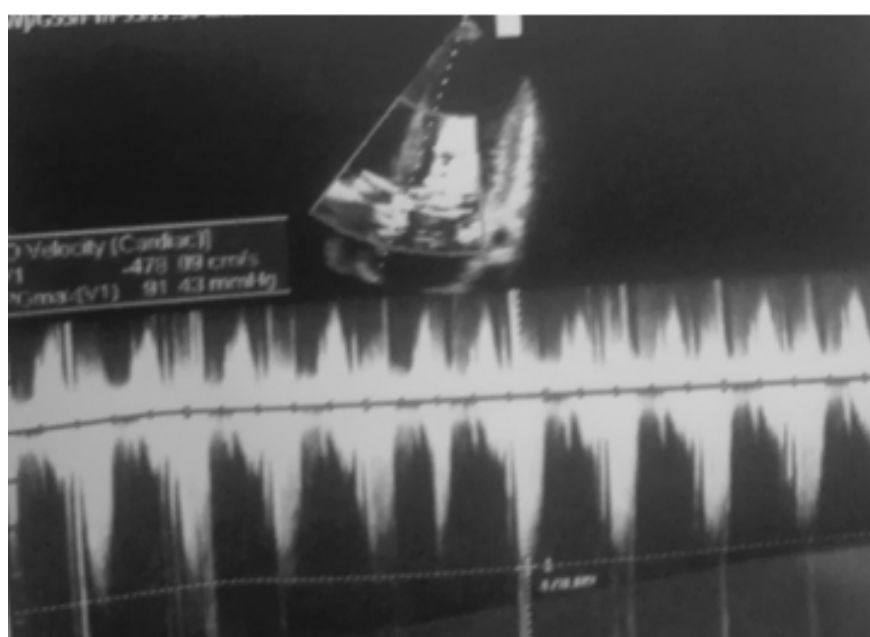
Pulsed doppler shows significant regurgitation
